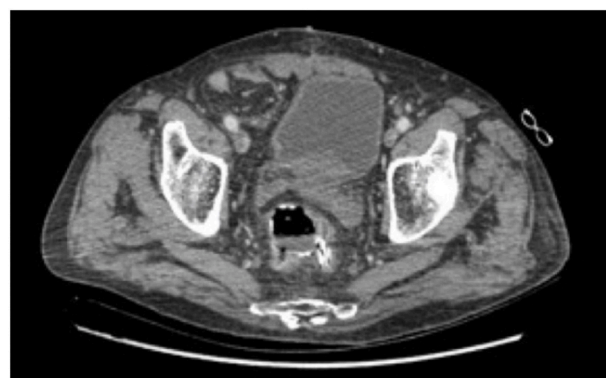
Postoperative CT-scan documenting interruption of the colorectal suture in anterior resection of the rectum for carcinoma.
